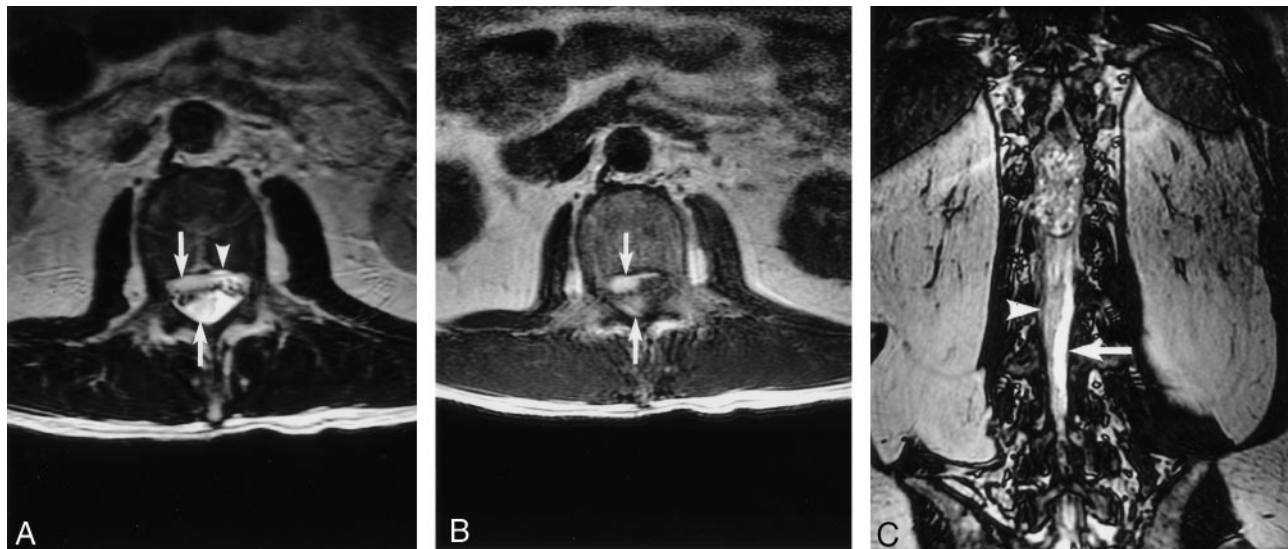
Spinal SDH. Axial T2- (A) and T1-weighted (B) images show hyperintense subdural blood collections located both anterior and posterior (arrows) to the cauda equina. Anteriorly, the subdural blood is separate from the epidural fat signal intensity (A, arrowhead). Coronal fast imaging employing steady-state acquisition (C) shows the posterior blood collection (arrowhead) is clearly separate from the hyperintense CSF (arrow).
